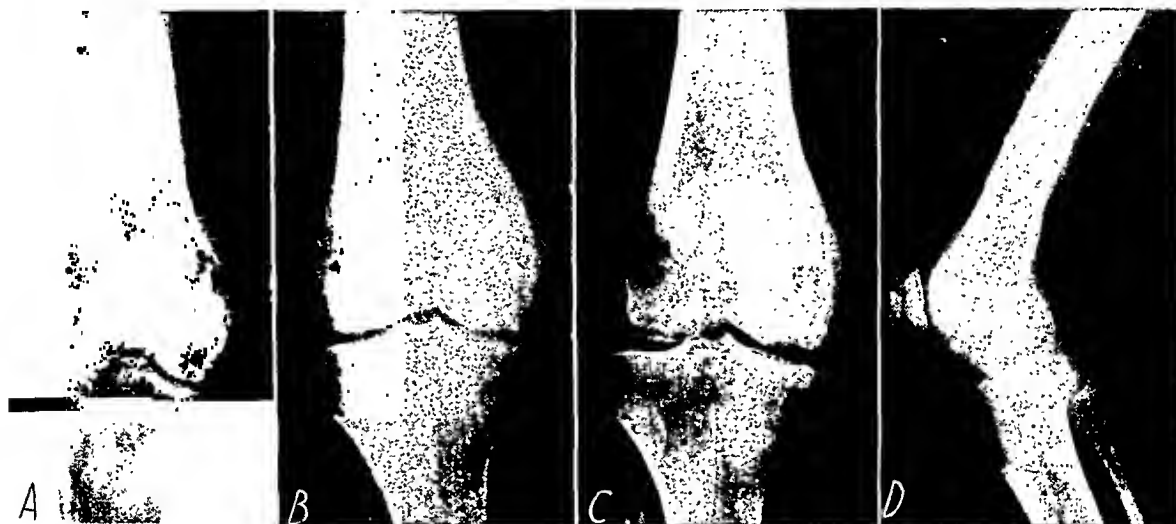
Case 2. *A*, initial roentgenogram showing tumor involving entire medial femoral condyle. *B*, response one year after treatment. *C*, four and one-half years after treatment. This is the usual appearance after radiation therapy for reticulum cell sarcoma. *D*, lateral view showing synovitis accompanying tumor demonstrated in *A*.
